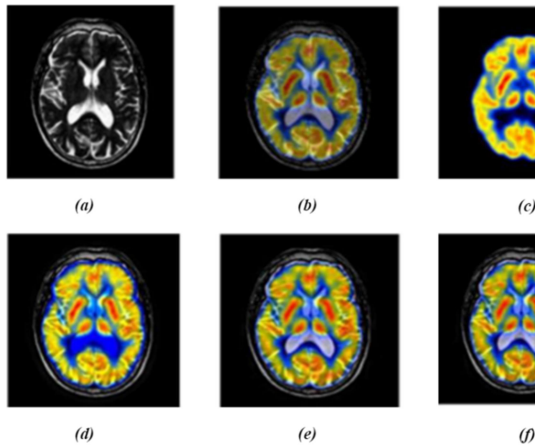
MRI-PET Resultants (a) ODNN, (b) Neuro-on, (c) HFCMK, (d) VAE, (e) EDF & (f) Dual-way F^2M^3 SLNN
